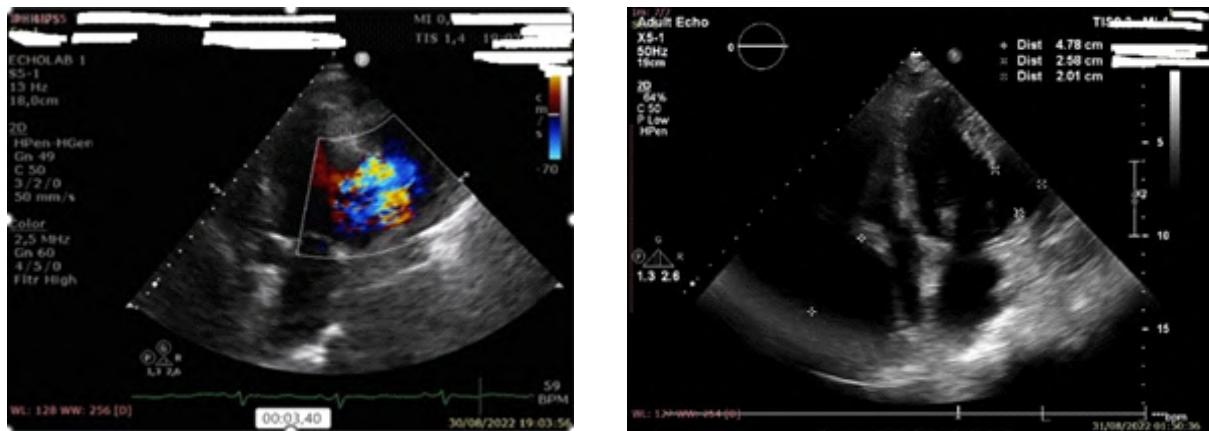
Echocardiography of Pseudoaneurysm (left) and Massive Pericardial Effusion (right)
